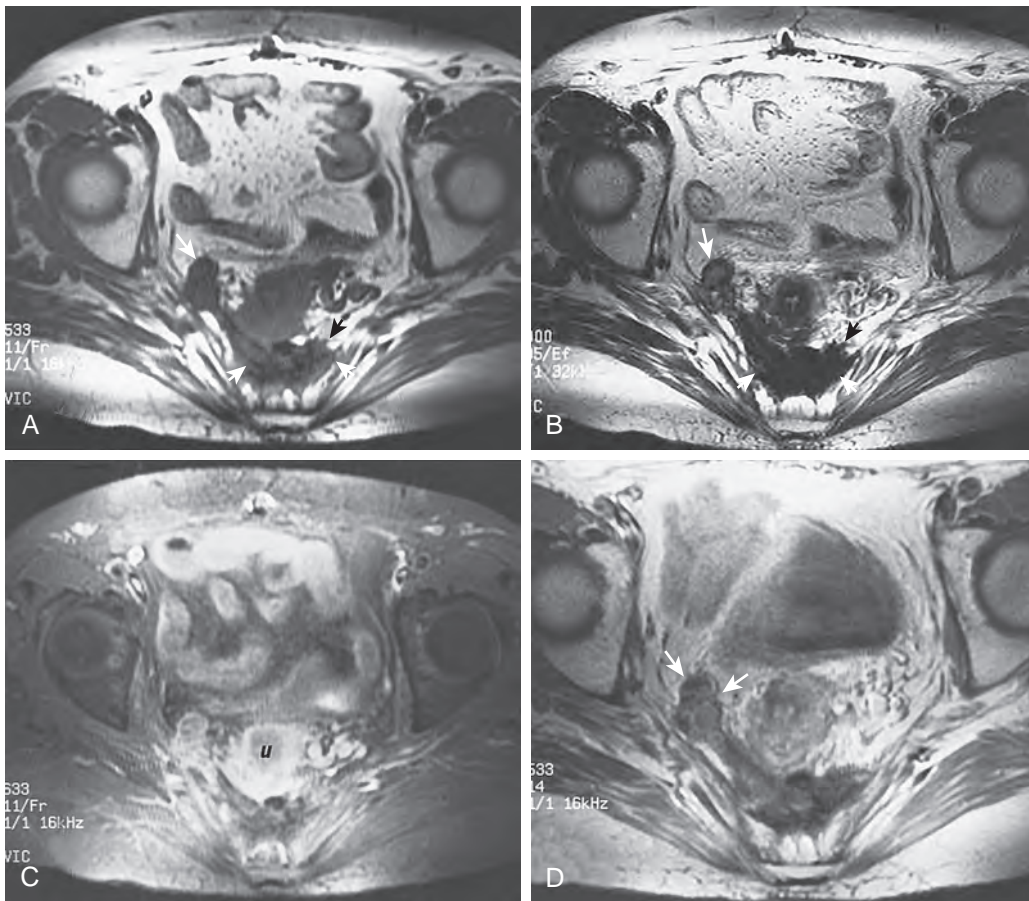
MRI scans of recurrent rectal carcinoma.
